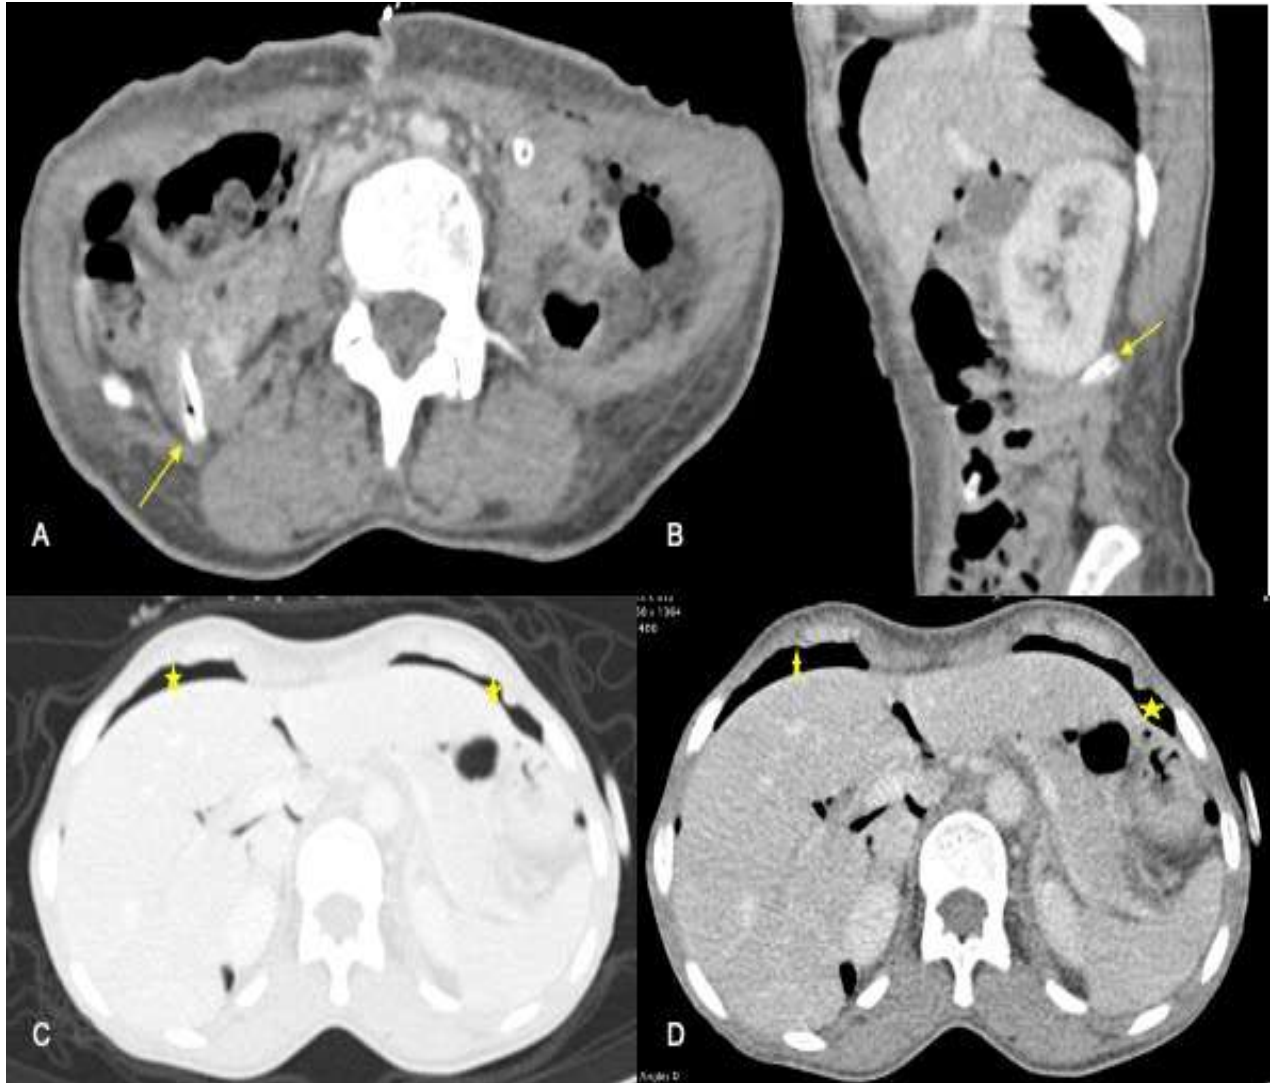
Abdominal enhanced CT scan at portal phase with axial (A,C and D) and sagittal reconstructions (B) showing a displacement of the jejunostomy tube outside the jejunum into the peritoneum (yellow arrow; A and B), associated with pneumoperitoneum (yellow star; C and D).
